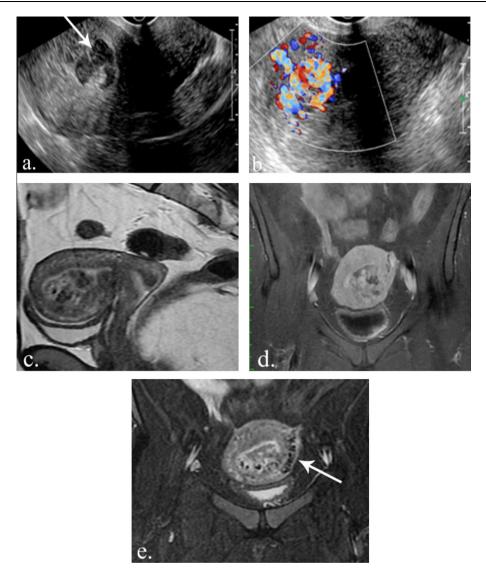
Uterine AVM: A 21 year old patient presented with vague pelvic pain and vaginal bleeding. (a) Gray Scale Transvaginal ultrasound revealed several interspersed sonolucent spaces of varying sizes close to the uterine fundus (arrow). (b) Endovaginal color Doppler sonogram reveals hypervascular nature of sonolucent spaces. Gestational trophoblastic disease was the ultrasound suggestion however pregnancy test was negative so further MRI examination was recommended. (c) Sagittal T2 weighted image revealed multiple serpiginous flow-related intense contrast enhancement in anterior myometrium corresponding to sonographic findings. (d) Contrast-enhanced fat-suppressed coronal fast spin-echo T1-weighted image during arterial phase also shows multiple serpiginous flow-related signal voids in myometrium (e) coronal STIR image better shows associated asymmetric prominence of contiguous signal void vessels on left (arrow) consistent with uterine AVM.
